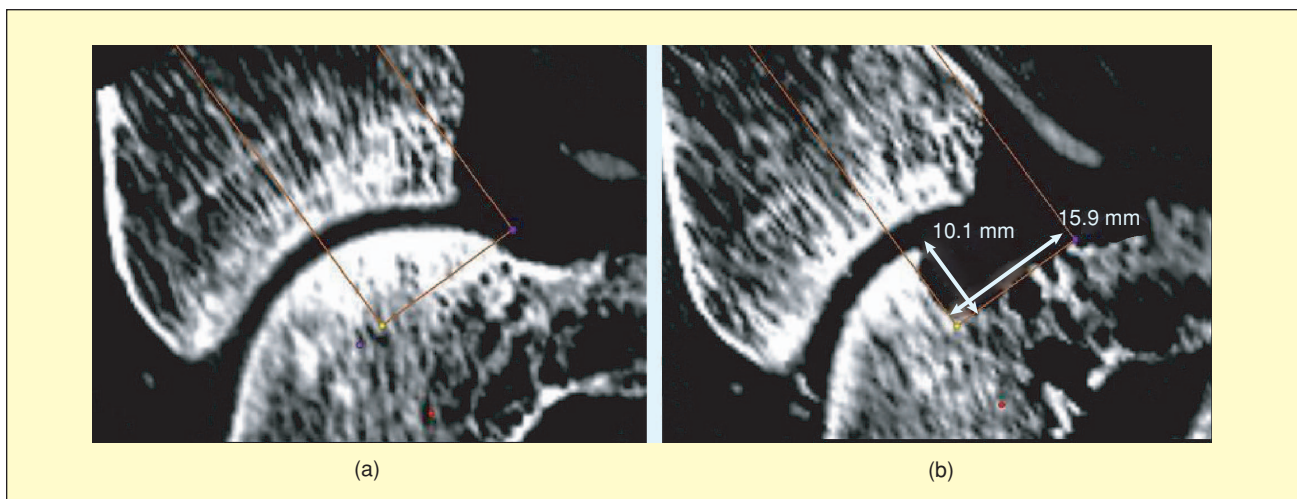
Lateral view of the operative result: (a) the planned profile and (b) the postoperative CT.
